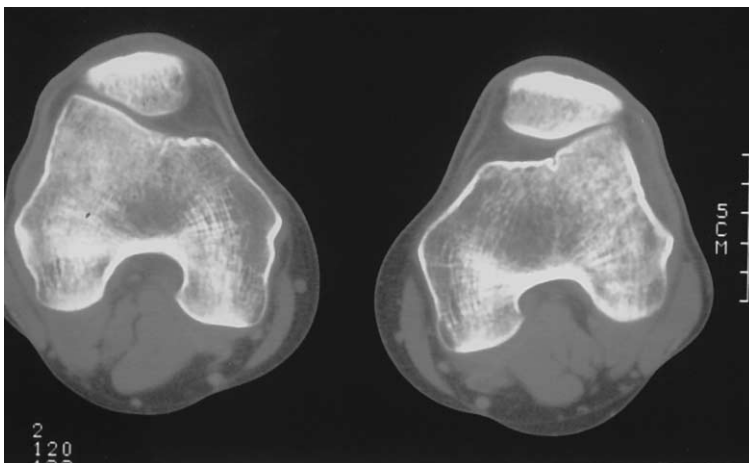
CT scan demonstrates increased pressure in the lateral patellofemoral joint.
